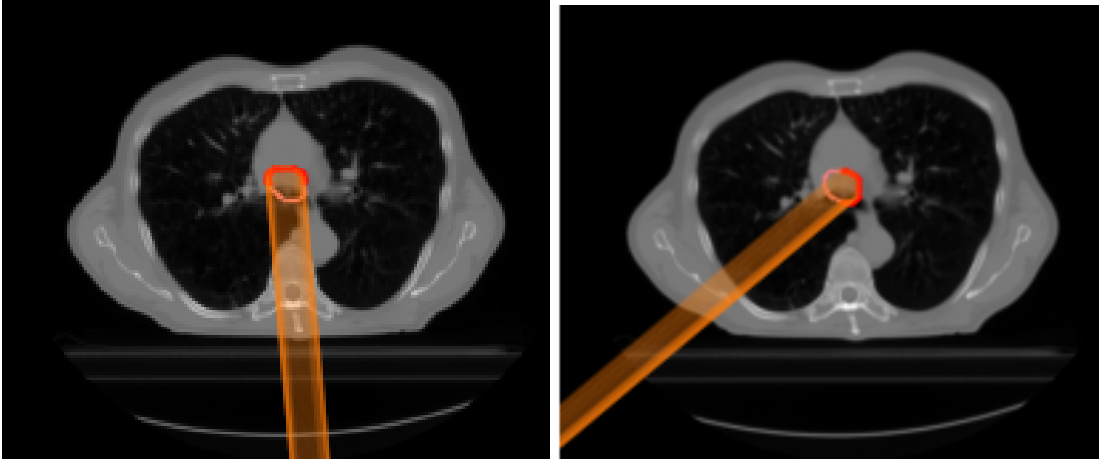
A CT image of one of the patients with the CTV delineated in coral and the distal edge of CTV in red. The WEPL was calculated along several individual paths (colored orange) from the outer edge of the image to every point on the distal edge of the CTV relative to the radiation field angle. Here shown for two different field angles.
